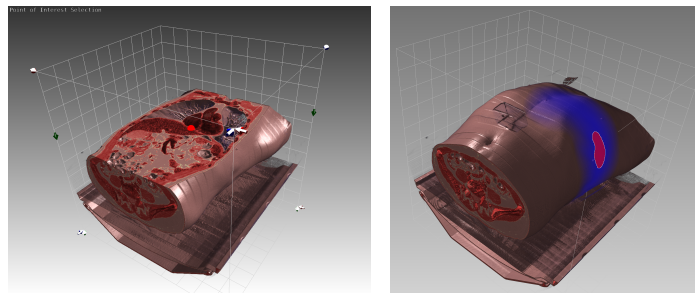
View port determination based on the planning CT. Left: manual target definition (red sphere). Right: Quality of ultrasonic view port (blue). The darker the color, the better the visibility of the target becomes. Optimal view port is shown in red. Figures from [1].
